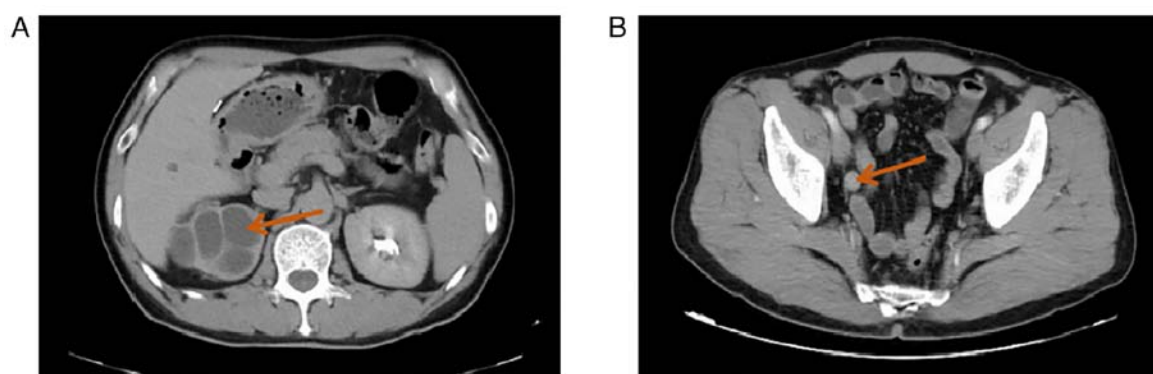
Computed tomography of the whole abdomen. (A) Hydronephrosis of the right kidney with multiple cysts in the right kidney and partial marginal calcification. (B) Occupational lesion in the right lower and middle ureter.
